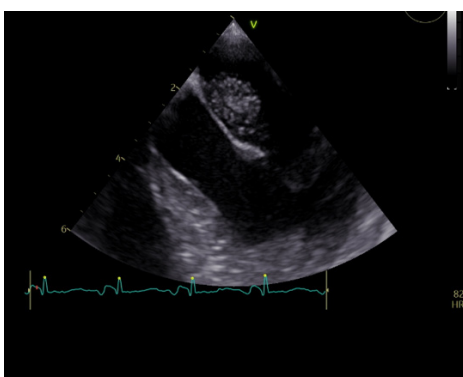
Echocardiogram showing intra atrial mass separate from the valve.
